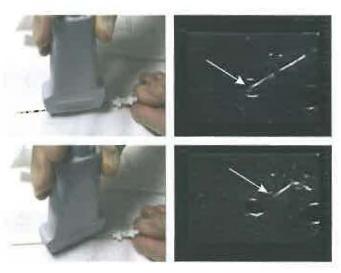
Proper versus improper needle alignment. Top: Needle aligned along the 1mm wide ultrasound plane allows for full visualization including its tip indicated by arrow. Bottom: Ultrasound image reveals a "false" needle tip when not aligned.
